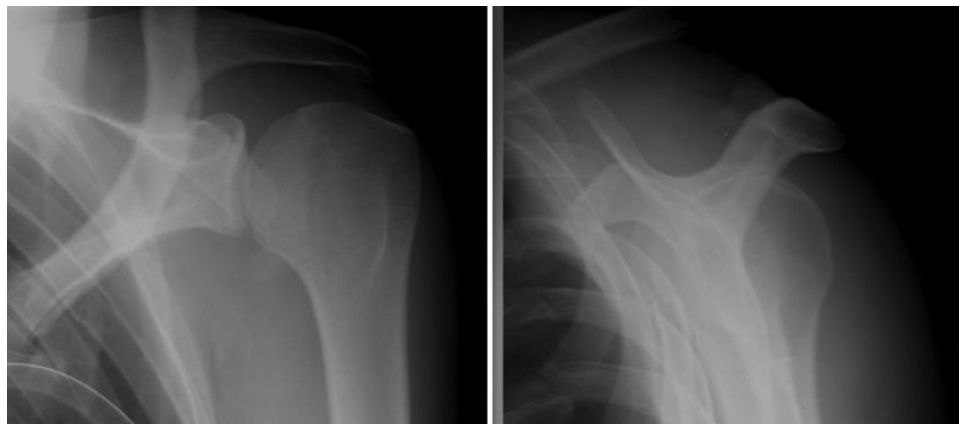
Radiograph at last follow-up.
